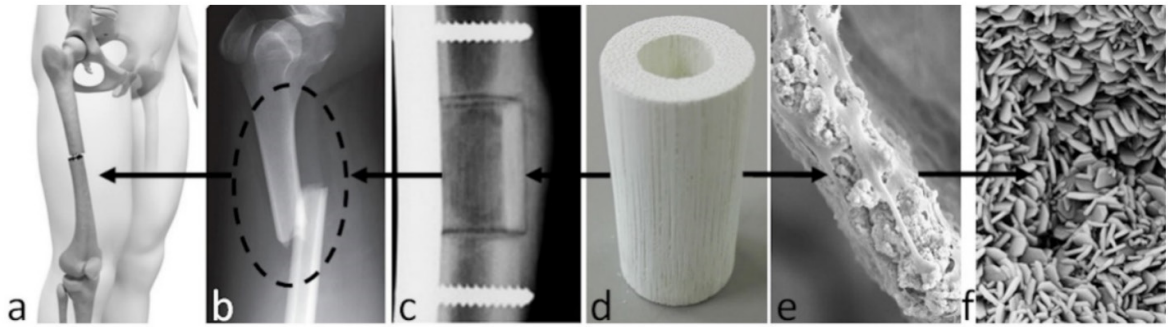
Biomimetic scaffolds for long bone regeneration and their application in long bone defects: (a) example of implantation site; (b) critical size defect; (c) radiography of implanted scaffold; (d) bone scaffold from wood; (e) scaffold–cell interaction, 250 \times ; (f) scaffold nanostructure, 25,000 \times ¹²⁷.
